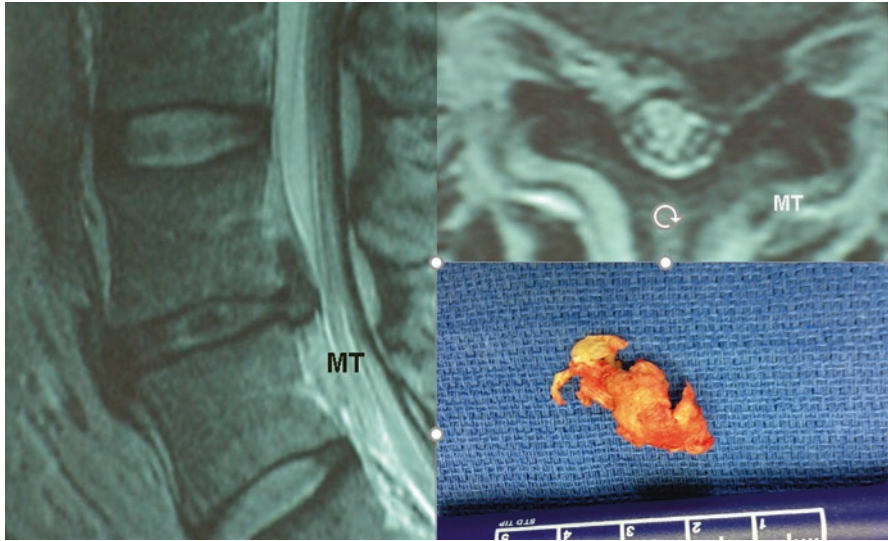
This is a 21-year-old division 1 defensive lineman presenting with 5 days of severe left buttock pain and numbness extending into the top of his foot. He had 4/5 strength and is left EHL and peroneals. Imaging in the left and top right panel are a T2 sagittal and axial MRI showing a large L4–L5 left paracentral disk herniation. The timing of the injury was 2 months prior to the start of his season. One epidural steroid injection was attempted with some relief of pain for a day, but his strength had not improved 1 week after the injection. Continued nonoperative treatment was offered, but the player wanted to have a chance to return for the upcoming season, and the motor deficit was concerning to the patient. A microdiscectomy was performed and the removed disk herniation is shown in the bottom right panel. The 2 weeks' postoperative visit showed a healed wound, improvement in motor strength, and no pain. Functional rehabilitation was performed, and in this motivated patient he was back to practice at the 2 months' postoperative time-point. He was able to return to play later that same season
